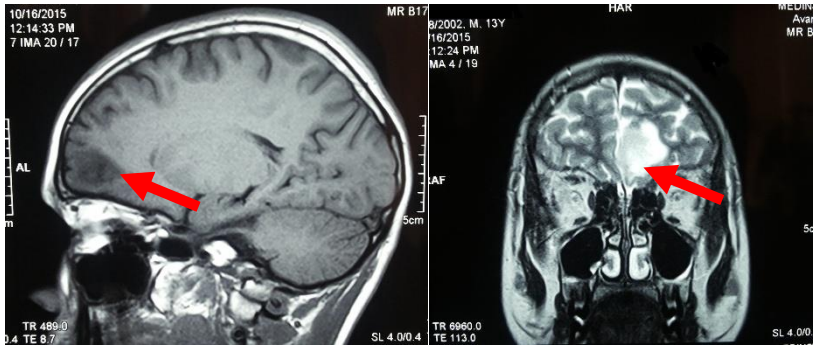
MRI: Sagittal and frontal section; Infiltrative tumor, left frontal-basal, grade II astrocytoma (Image source: Modified after 13)
